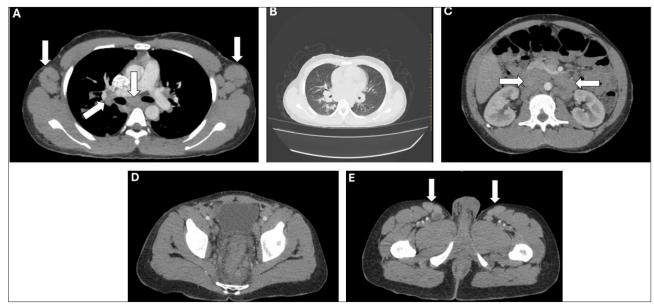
Contrast computed tomography scan of the chest (A and B), abdomen (C) and pelvis (D and E). Note the solid bi-axillary, right hilar and subcarinal lymphadenopathy (arrows, panel A). Also, the right lower lobe in B shows apical segment nodularity suggestive of post-primary tuberculosis. Abdominal and pelvic images reveal extensive solid para-aortic, para-carval and paravertebral lymphadenopathy (C) and solid and necrotic bi-inguinal lymphadenopathy (D). Peri-anal and perirectal oedema and regional enhancing lymphadenopathy was observed (E), in keeping with severe proctitis.
